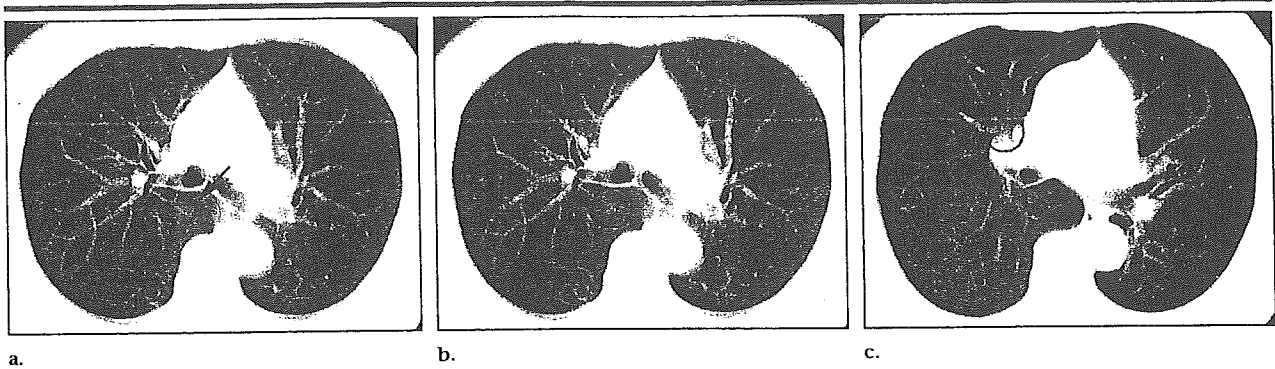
Images obtained in a 69-year-old woman in whom CAD was helpful. Transverse CT scans show (a) a missed lung cancer (arrow) with pure GGO in the right upper lobe, (b) the cancer, and (c) a false-positive finding. Circles in b and c indicate the computer detections. In this patient, 10 radiologists did not detect the cancer without CAD, whereas CAD helped seven radiologists find the cancer.
